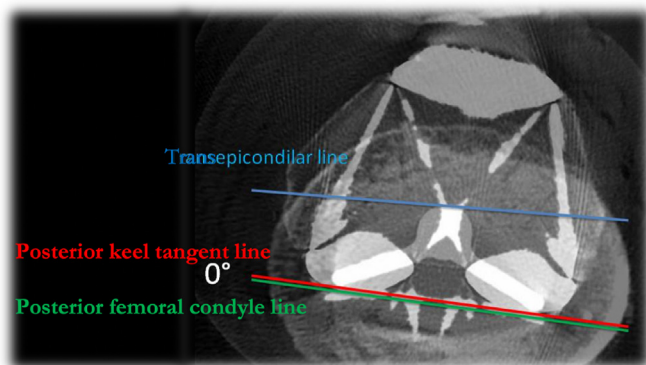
Superimposition of the axial CT femoral component slide where the surgical transepicondylar axis (TEA) and posterior femoral condyle (PFC) were taken, and the axial CT tibial component slide at the level of the posterior tibial component keel. The reciprocal femorotibial rotation (RftR) is defined as the angle between the projected PFC on the tibial base plate and the posterior keel line. In this specific case, the RftR is 0°. CT, computed tomography.
